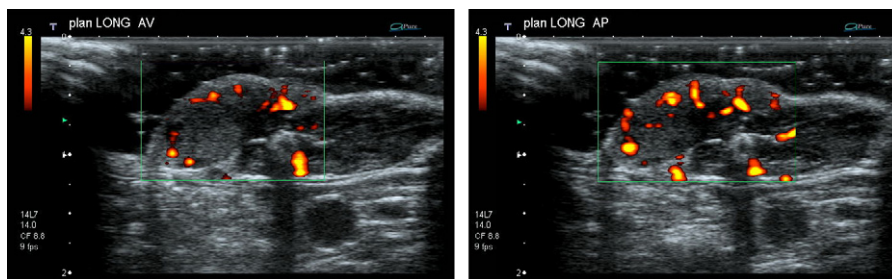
Examples of intratumoral vessels observed in melanoma tumor scans in Doppler power mode before and after trisacryl particles injection.
